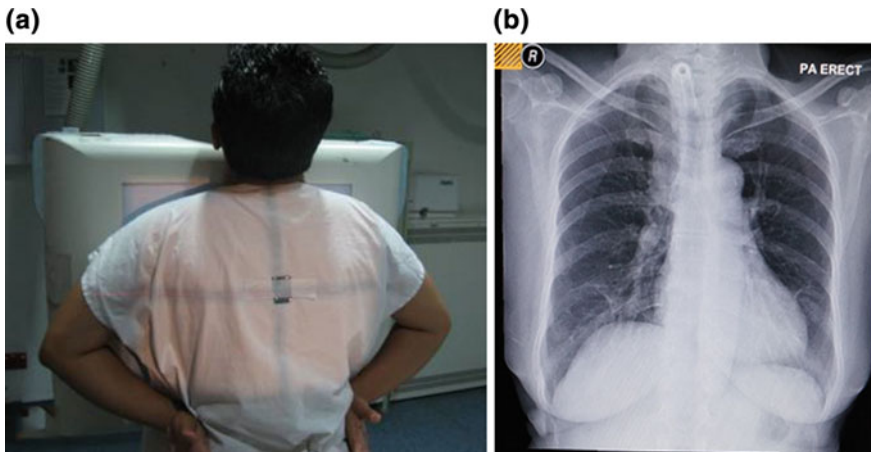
a Chest PA projection and its b radiograph image
